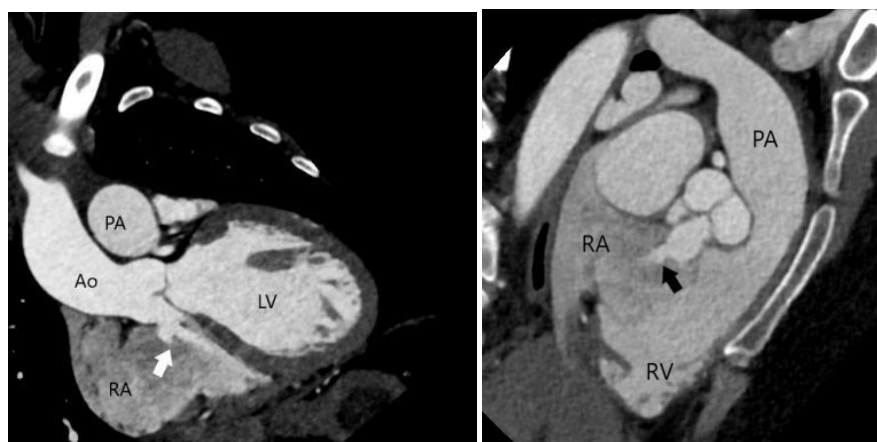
Orthogonal planes of gated cardiac CTA demonstrate a noncoronary sinus of Valsalva aneurysm that has ruptured into the right atrium (white arrow). A jet of contrast through the defect into the right atrium is also seen (black arrow).
